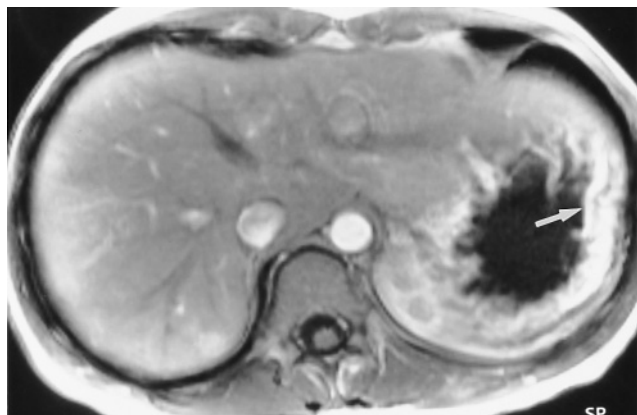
Gastric wall hyperplasia. Immediate postgadolinium T1-weighted SGE image demonstrates intense enhancement of the prominent gastric rugal folds (arrow) in a patient with gastrinoma.
